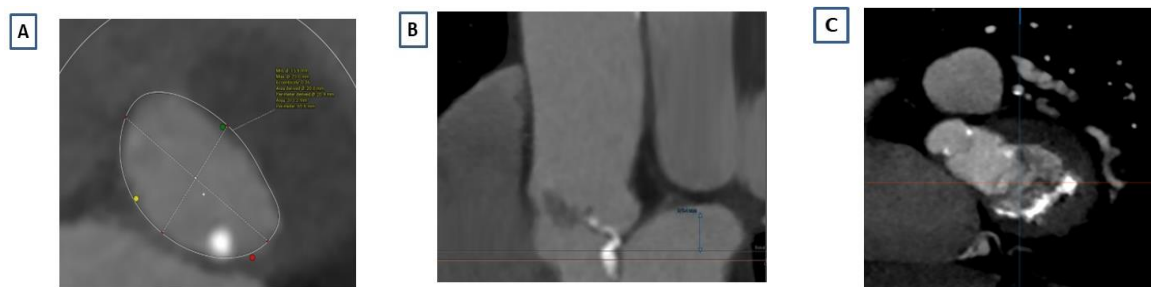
Example of CT analysis of patient who required PPM post-TAVI. The annular dimension CT analysis [A] with short membranous septum length [B] and severe mitral annular calcification [C]
